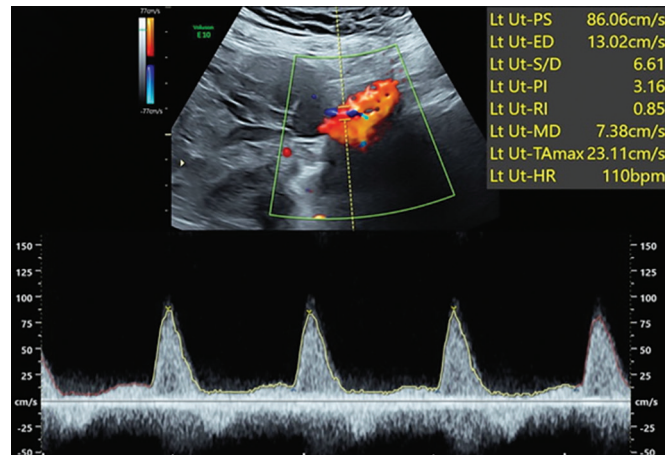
Doppler of increased flow resistance
